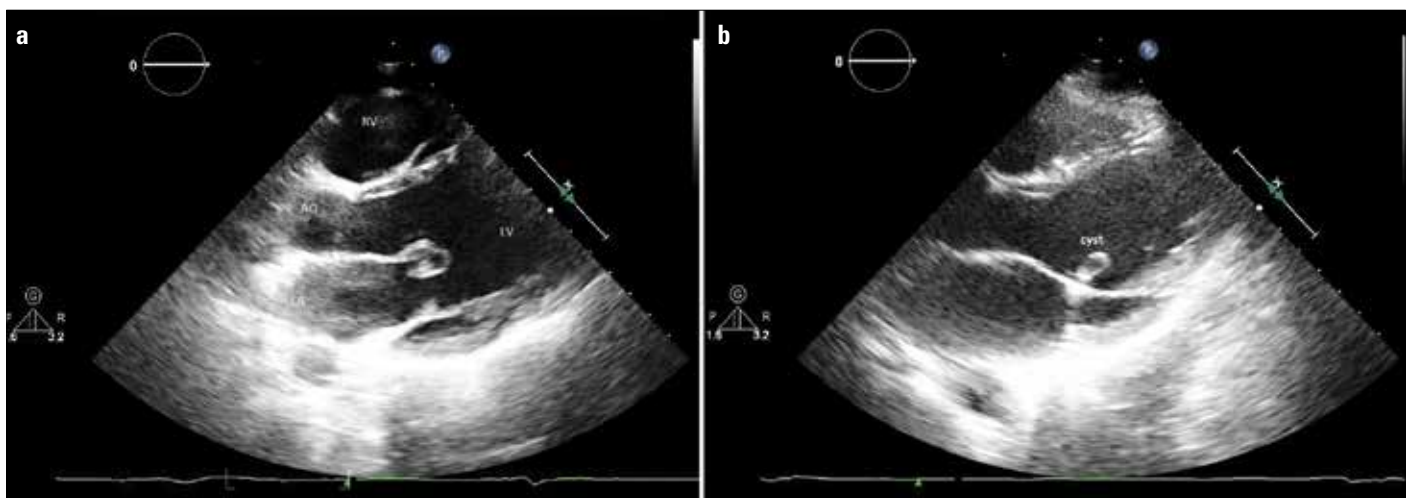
a, b. Transthoracic echocardiographic image showing a blood cyst on the anterior leaflet of the mitral valve (parasternal long-axis view)
